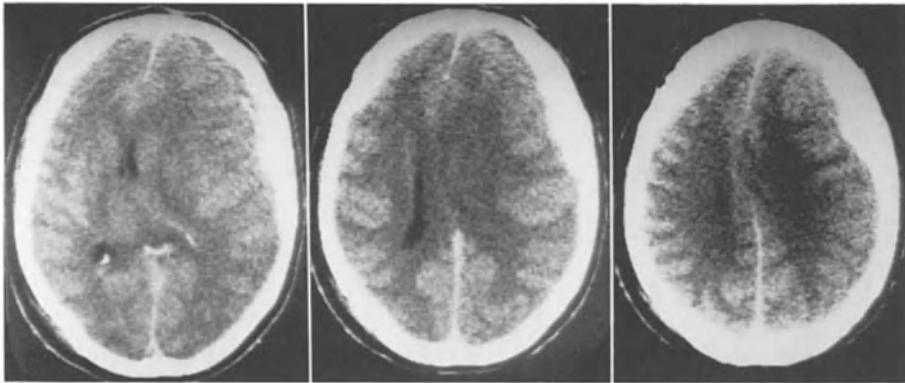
This 22 year-old man injured in a traffic accident lost consciousness at the moment of the impact. Associated extracranial injuries caused arterial hypotension and hypoxia. He arrived in our unit 3 hours after injury showing bilateral fixed dilated pupils and a motor score of 2. The admission CT scan showed a laminar subdural haematoma which was immediately evacuated; the preoperative midline shift, which was disproportionate for the size of the clot, did not change after the operation. ICP was above 35 mmHg leading to patient's death on the third day after trauma
